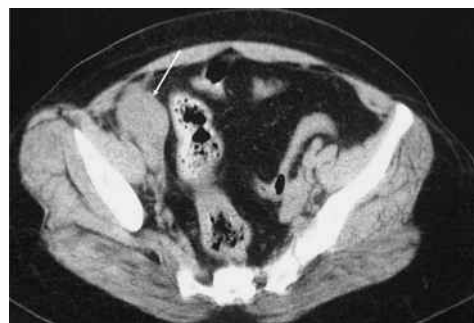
Axial CT image shows a well-defined right lower quadrant soft tissue mass lesion (arrow) anterior to the right iliac vessels. The normal appendix is not seen. Diagnosis at surgery was right tubo-ovarian abscess.
